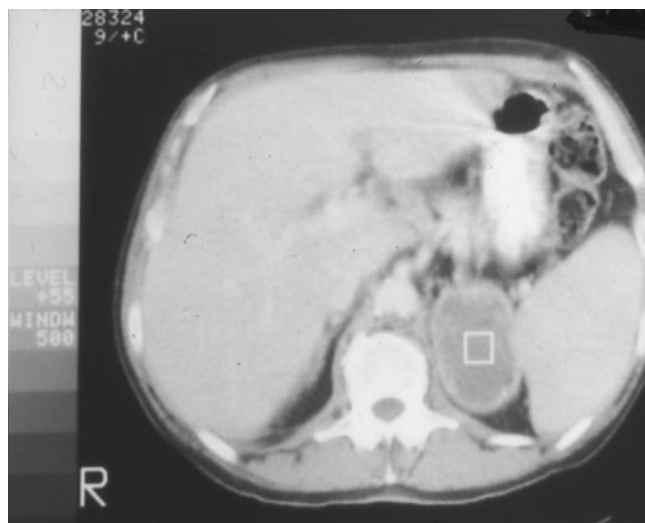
Abdominal CT scan showing adrenal enlargement with central necrosis in a patient with chronic progressive histoplasmosis complicated by Addison's disease
